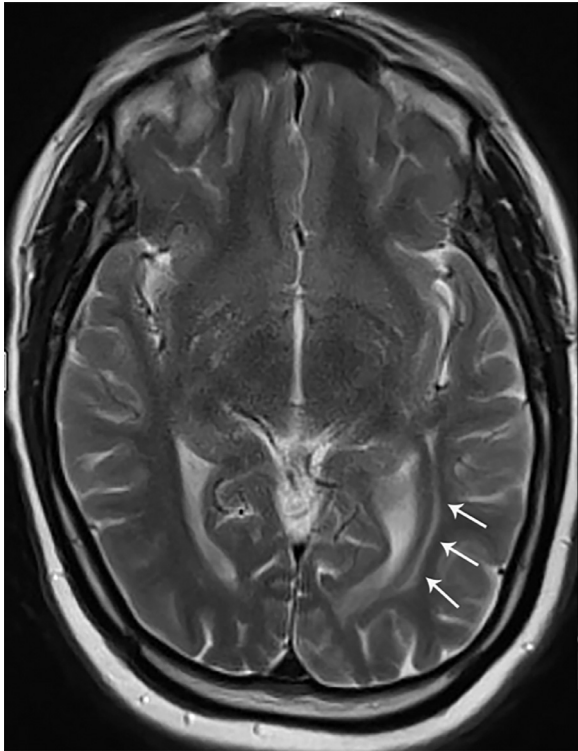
Axial T2-weighted image (repetition time ms/echo time msec 3140/105) shows hyperintense signal along the course of the left optic radiations (arrows) suggestive of trans-synaptic degeneration.
